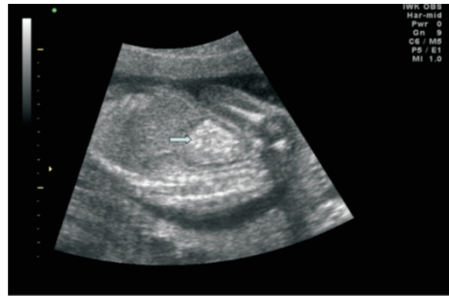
Fetal echogenic bowel on ultrasound.
